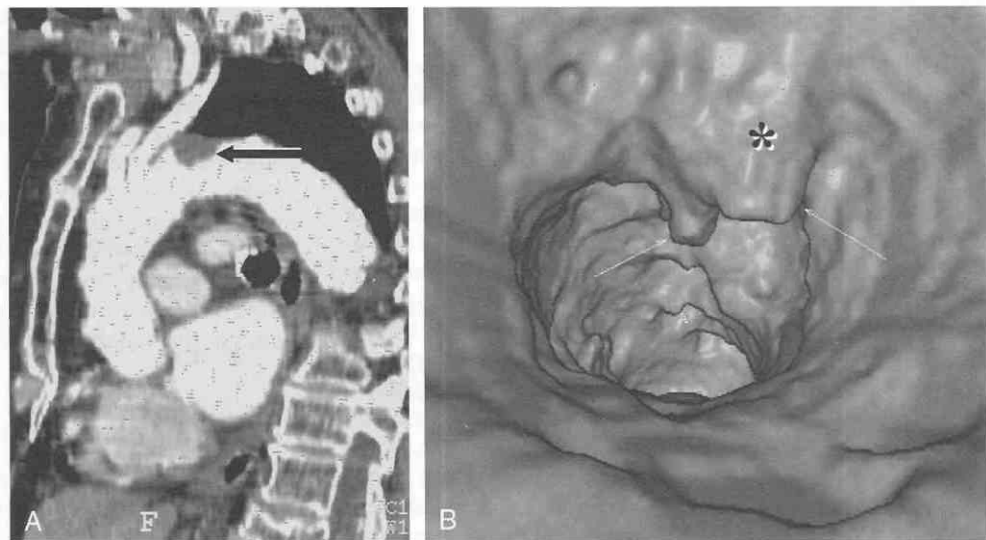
A, Sagittal oblique multiplanar reconstruction from multislice CT scan in a patient with a splenic infarct and arm weakness. There is a polypoid atheroma within the transverse arch (arrow). B, Virtual endoscopic image of the aortic arch shows a pedunculated atheroma (arrow) within the arch.
